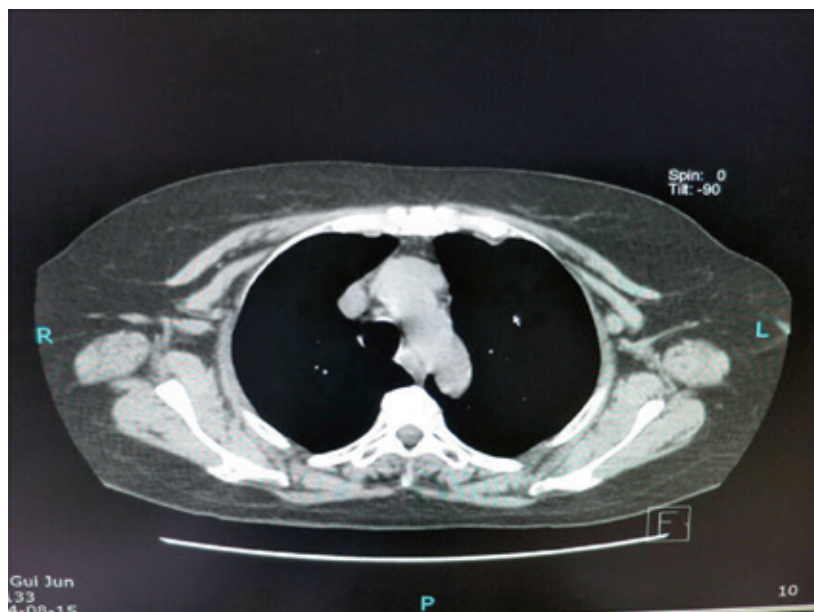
Computed tomography of the chest showing a mass in the right anterior mediastinum (case 2)
